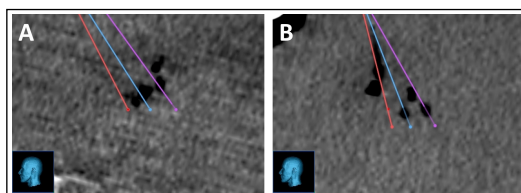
Variation in intracerebral air deposits seen on CT.
